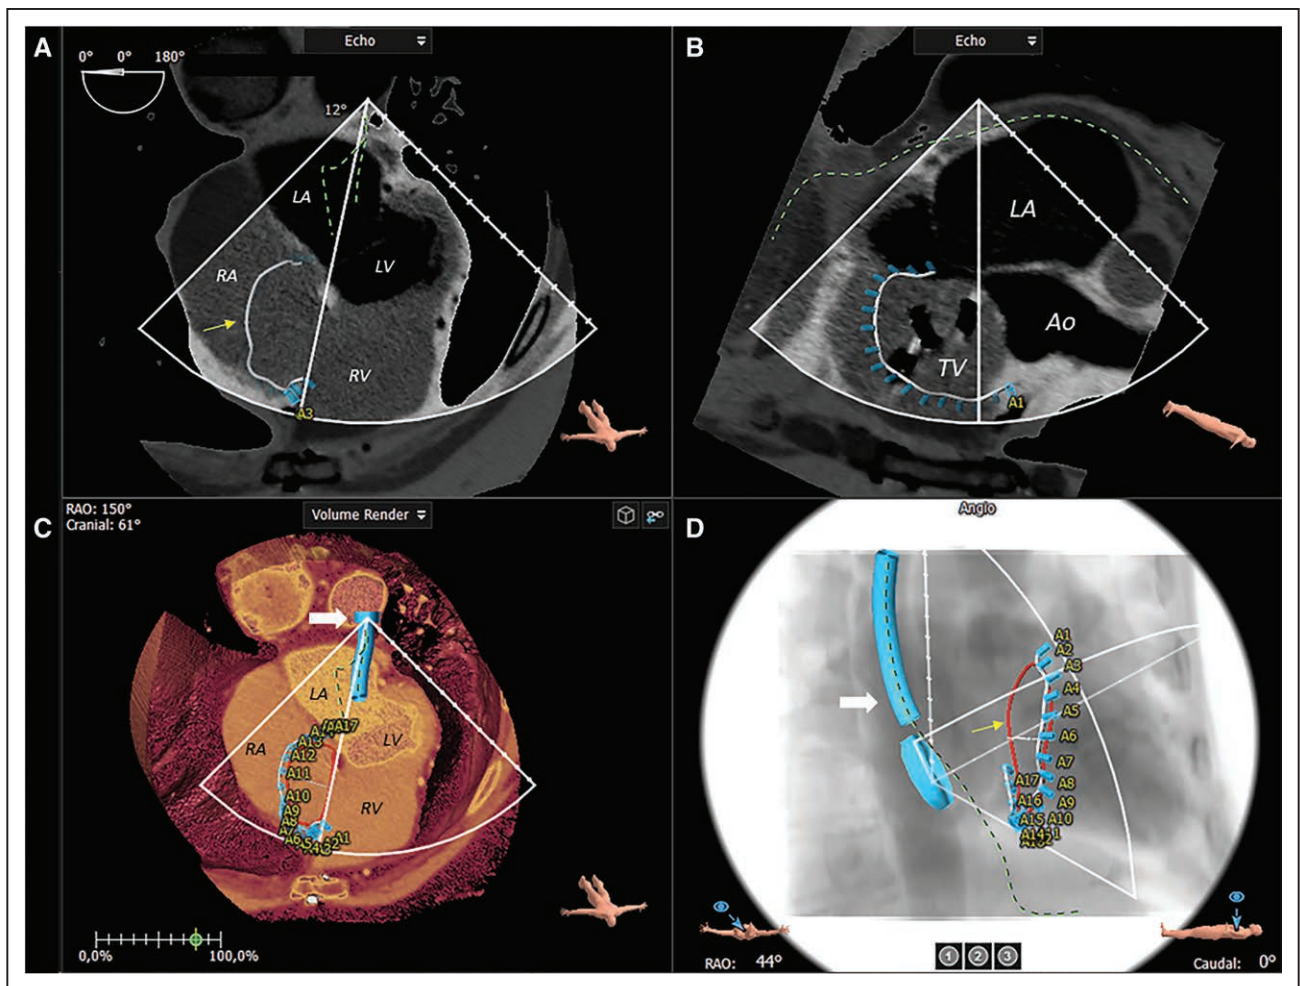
Computed tomography-derived transesophageal echocardiography (TEE) views for preprocedural planning of transcatheter tricuspid valve (TV) annuloplasty.
